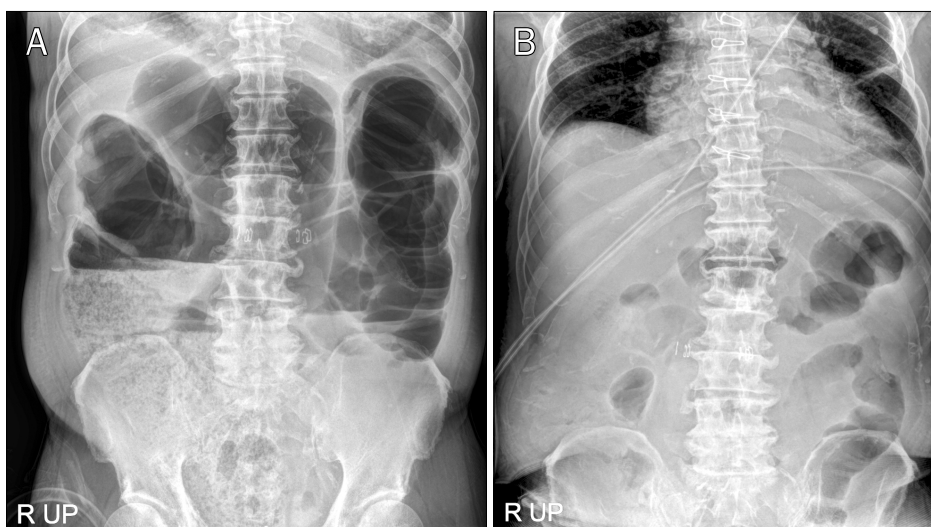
Plain abdominal radiographs. (A) Upon arrival at the emergency room, plain abdominal radiograph demonstrated diffuse dilated loops and dilatation of the cecum up to 11.5 cm in diameter. (B) A plain abdominal radiograph obtained 24 hours after administration of neostigmine showed evacuation of stool and complete resolution of bowel distension.
